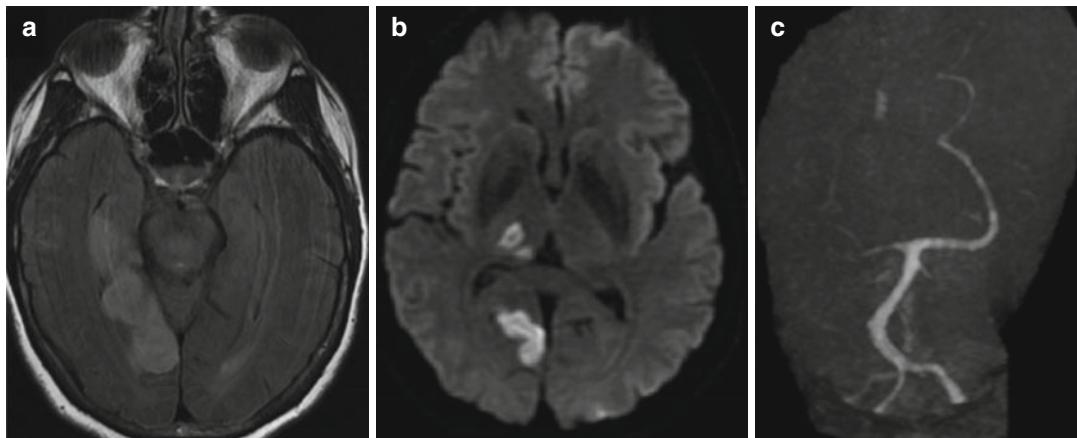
Ischemic stroke in a patient on hormonal therapy (anastrozole). The patient had been treated for breast cancer 3 years previously and was considered in remission. No other etiology or risk factor was found. MRI reveals a
